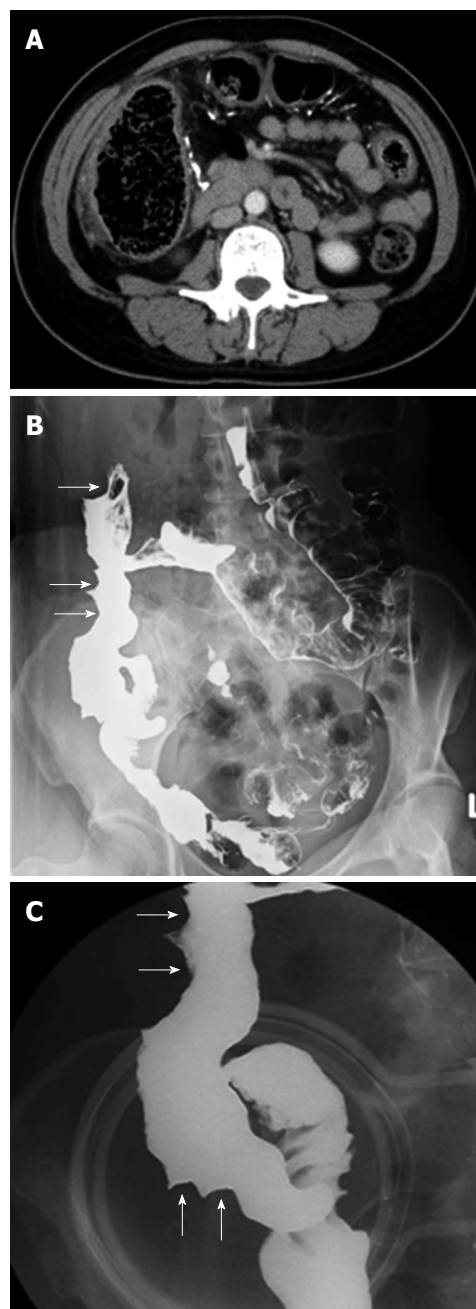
Barium follow-through study and intravenous contrast enhanced computed tomography. A 54-year old female suffered from abdominal pain and constipation. A: The contrast enhanced abdominal computed tomography shows calcifications at tributaries of mesenteric vein and dilatation of the ascending colon; B: The barium follow-through study done after discharge shows thumb-printing appearance (arrows) at the ascending colon; C: The close view of cone compression.
